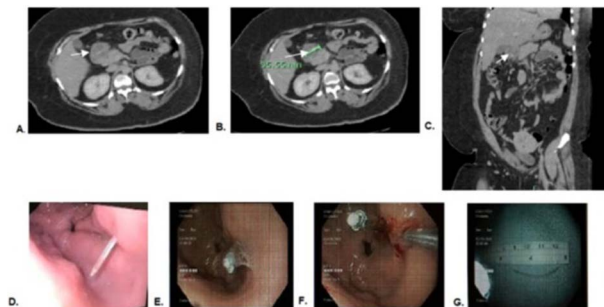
Figure A-C: Coronal view of a computed tomography (CT) image showing a linear, hyperdense, foreign body (arrow), which appeared to lodge in posterior wall of gastric antrum.
